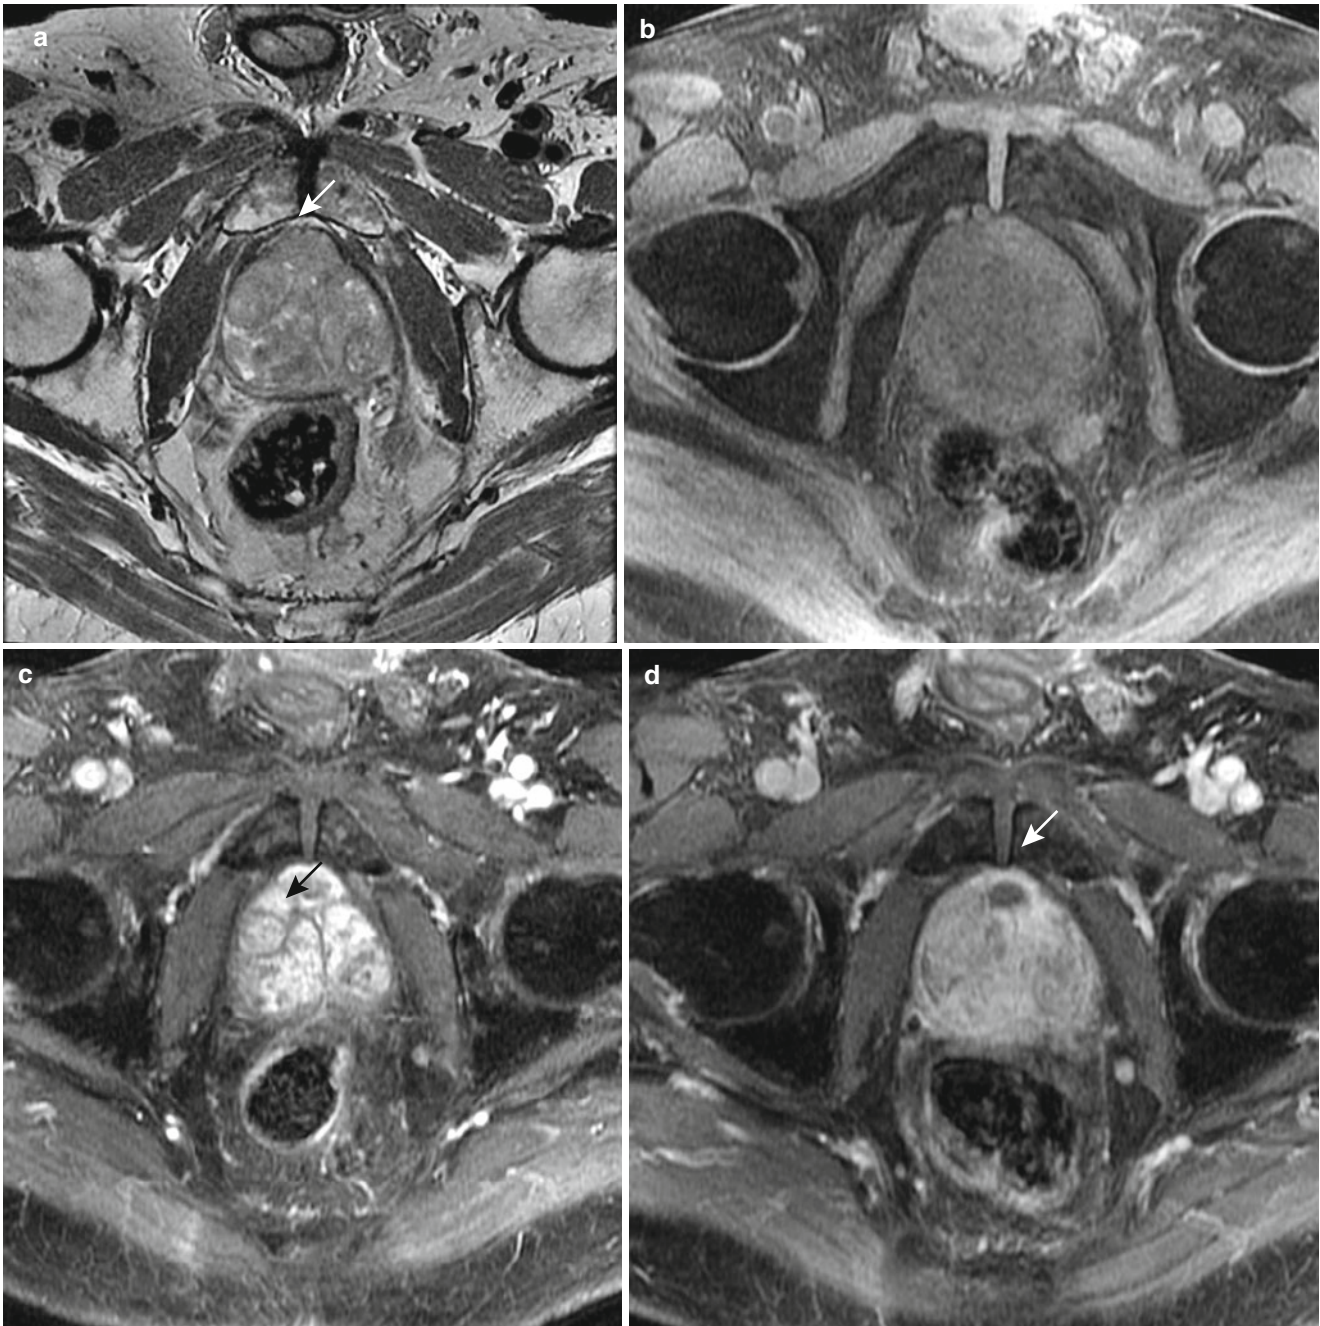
(a) T2-weighted image of low signal in the anterior transitional zone. (b) Pre-contrast image of the prostate. (c) 30–90-s
